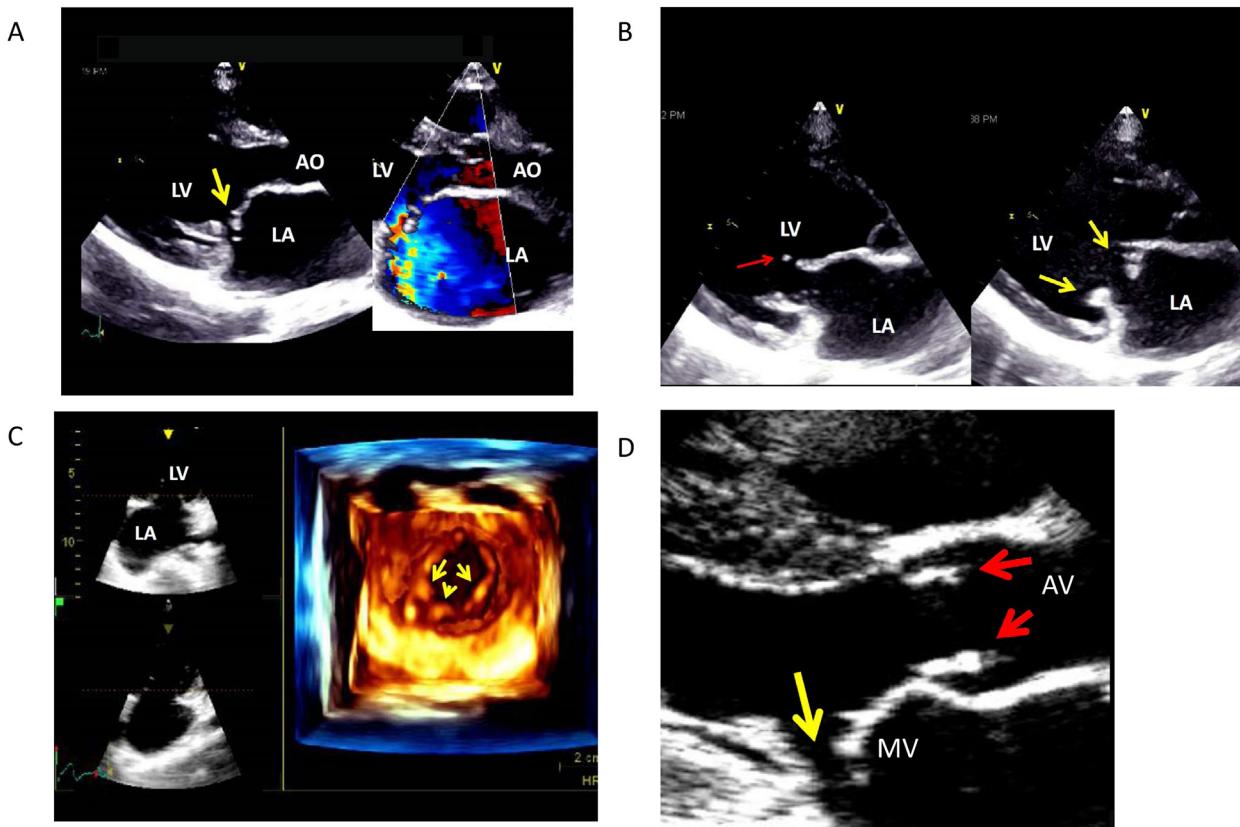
Example of rheumatic mitral valvulitis. (A) Transthoracic echocardiographic parasternal long-axis views in a 10-year-old boy with recent onset dyspnea, showing flail anterior mitral leaflet (arrow in left panel) and severe mitral regurgitation (right panel). (B) Parasternal long-axis view in different phases of diastole in the same patient. Note the chordal tear (red arrow) and nodular thickening of both leaflets (yellow arrows). (C) 3D en-face view of the mitral orifice at the level of leaflet tips showing nodular thickening of both leaflets (arrows) in diastole in the same patient. (D) Parasternal long-axis view in systole demonstrating nodular thickening of the aortic leaflets (red arrows) in addition to the aforementioned mitral valve findings (yellow arrow).
